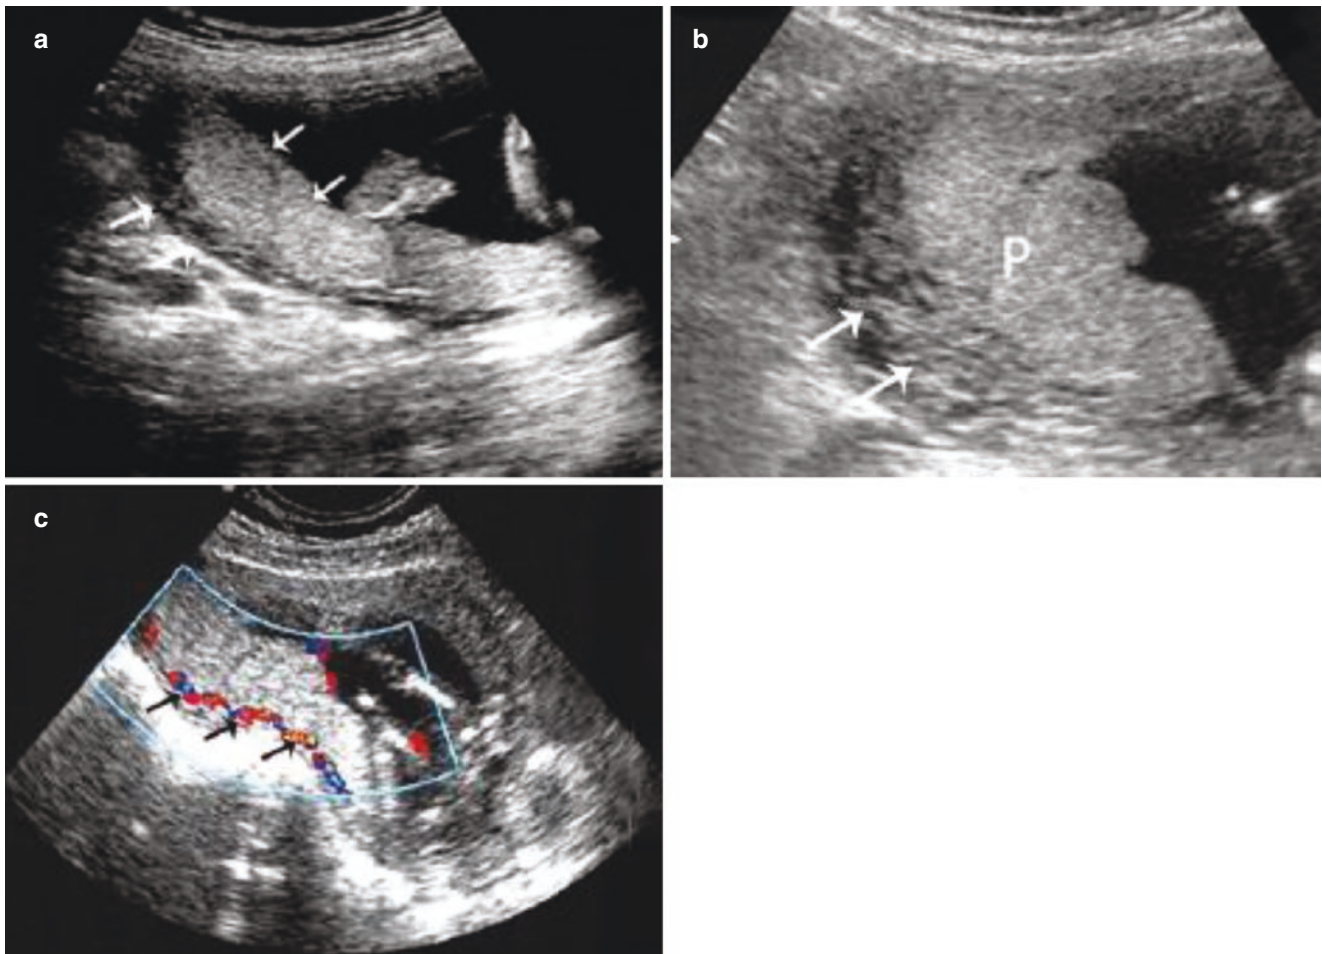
Normal placenta. (a). Maternal side, parenchyma, and fetal side of the placenta; (b). Vena plexus in the retroplacental space appears hypoechoic; (c). The retroplacental space blood flow is shown by color Doppler ultrasound
